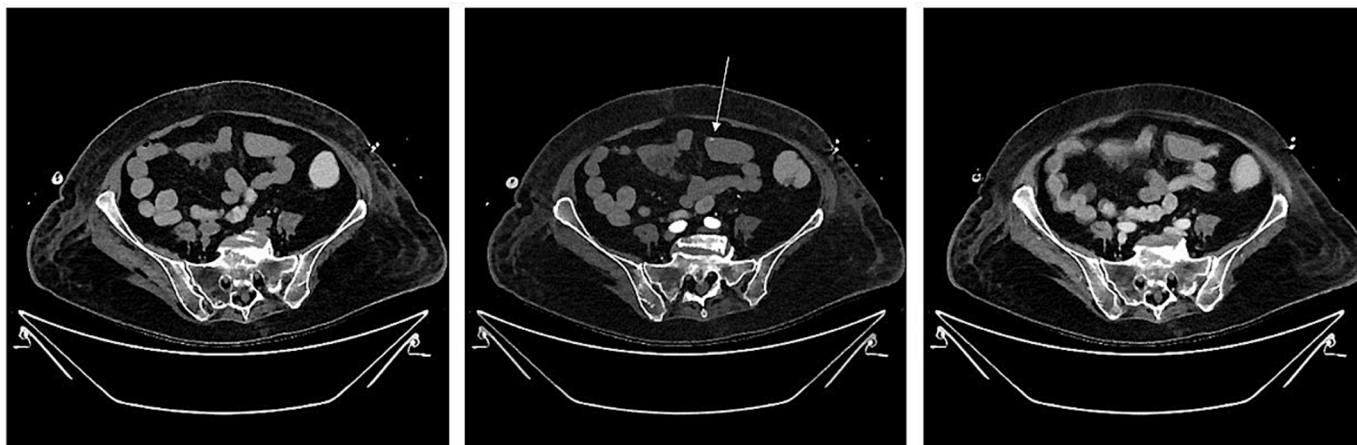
Case 1: Axial slice from a CT of the lower abdomen in non-contrast (left image), arterial (middle image) and portal venous phase (right image). Non-contrast scan was assessed as helpful to safely identify the arterial phase hyperdensity in a distal jejunal loop (white arrow) without venous pooling as contrast extravasation, as it was not present in the non-contrast scan.
